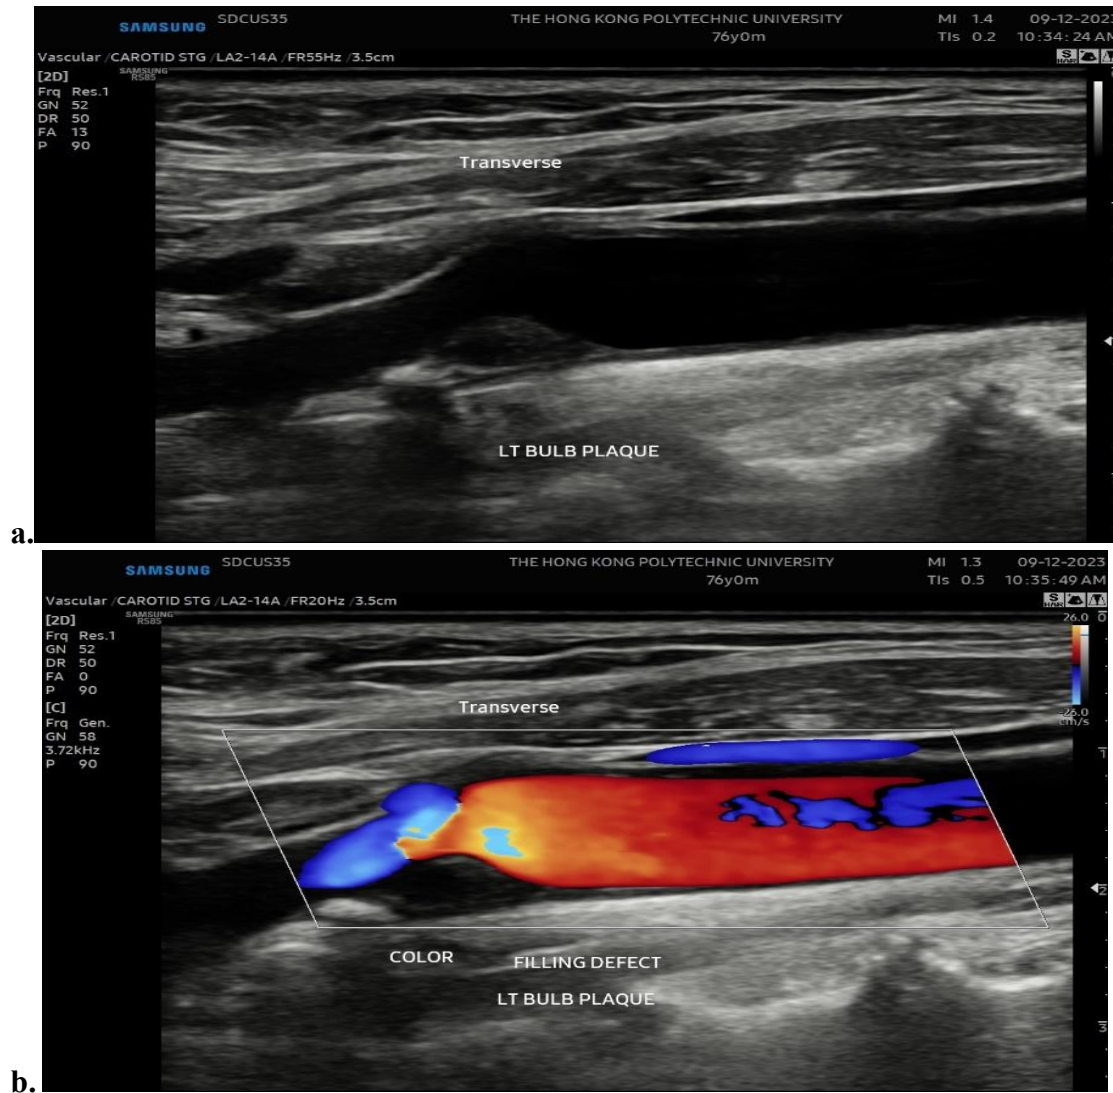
a.) Image showing the presence of a predominantly hypoechoic plaque in the carotid bulb encroaching into the ICA b.) corresponding color doppler image showing a filling defect.
